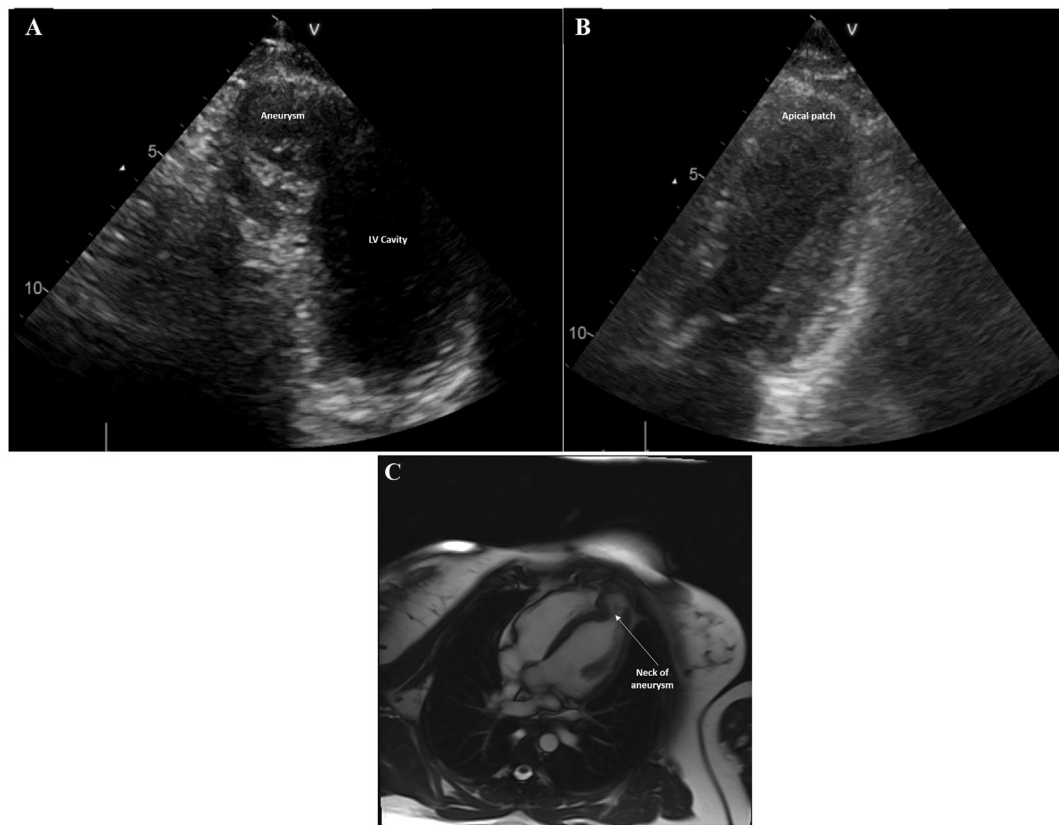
(A) Preprocedure echocardiography showing ventricular apical pseudoaneurysm; (B) postprocedure echocardiography after surgical resection of pseudoaneurysm; and (C) preprocedure cardiac magnetic resonance imaging (MRI) scan showing left ventricular (LV) apical aneurysm.
